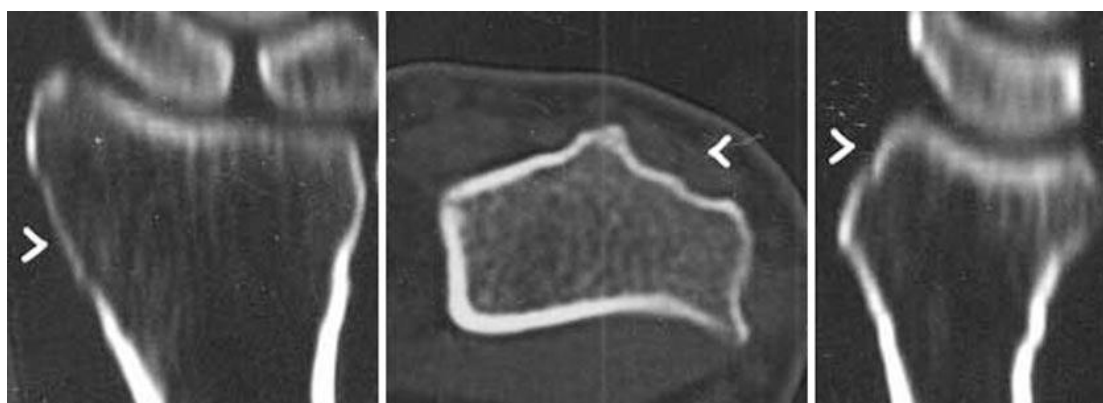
CT of the distal radius of a 49 years-old man showing the thickness of the cortical bone. Note the thin cortical bone on the dorsal and radial border [8].
